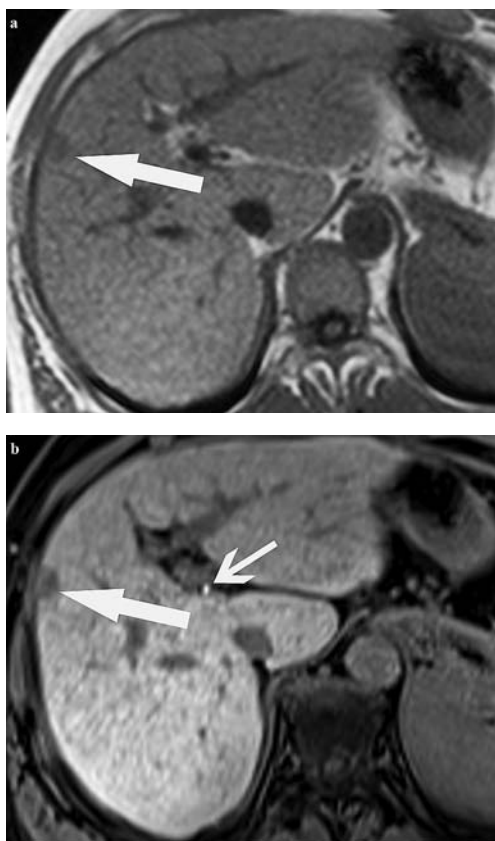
Hepatocellular carcinoma in a 49-year-old woman. Dynamic-enhanced MR imaging and hepatobiliary phase MR imaging with Gd-EOB-DTPA. Axial unenhanced T1-weighted image (a) demonstrates a small hypointense subcapsular nodule (arrow). Axial T1-weighted fat-suppressed image (b) acquired in the hepatobiliary phase 20 minutes after Gd-EOB-DTPA administration shows that the lesion (arrow) demonstrates no uptake of Gd-EOB-DTPA. Surgical resection yielded HCC. Note concomitant excretion of Gd-EOB-DTPA in the biliary tree (small arrow in b).
